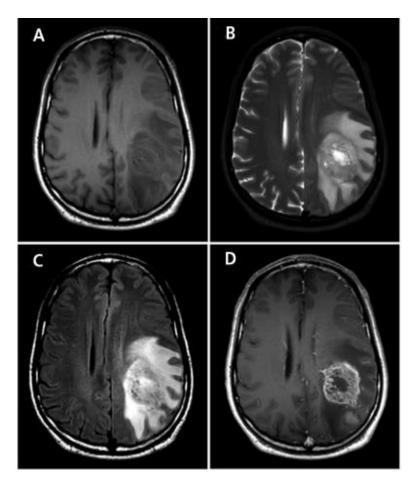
MRI images show a large mass in a patient presenting with hemiparesis on the right side. (A) T1weighted image shows a hypointensity lesion in the left frontal-parietal region. (B, C) T2-weighted and fluidattenuated inversion recovery images show a heterogeneous hyperintensity lesion with surrounding edema. (D) T1weighted image with contrast shows a heterogeneous ring enhancing lesion, a second area of enhancement posterior to the major lesion, and vasogenic edema. Pathology was consistent with glioblastoma. ⁽³¹⁾
